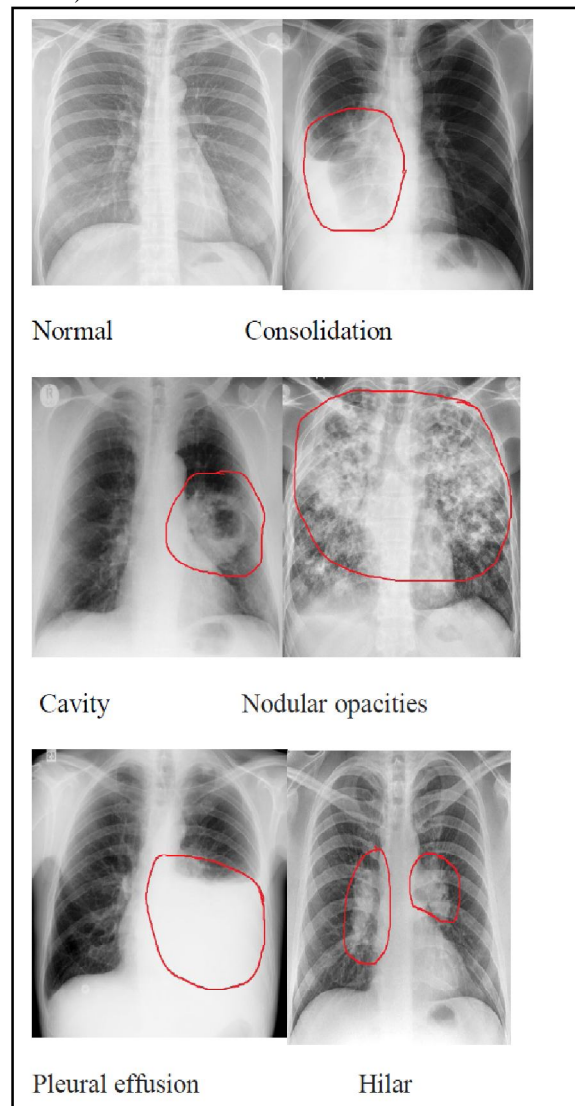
Radiological Manifestations of Pulmonary Tuberculosis on Chest X-Ray Images
